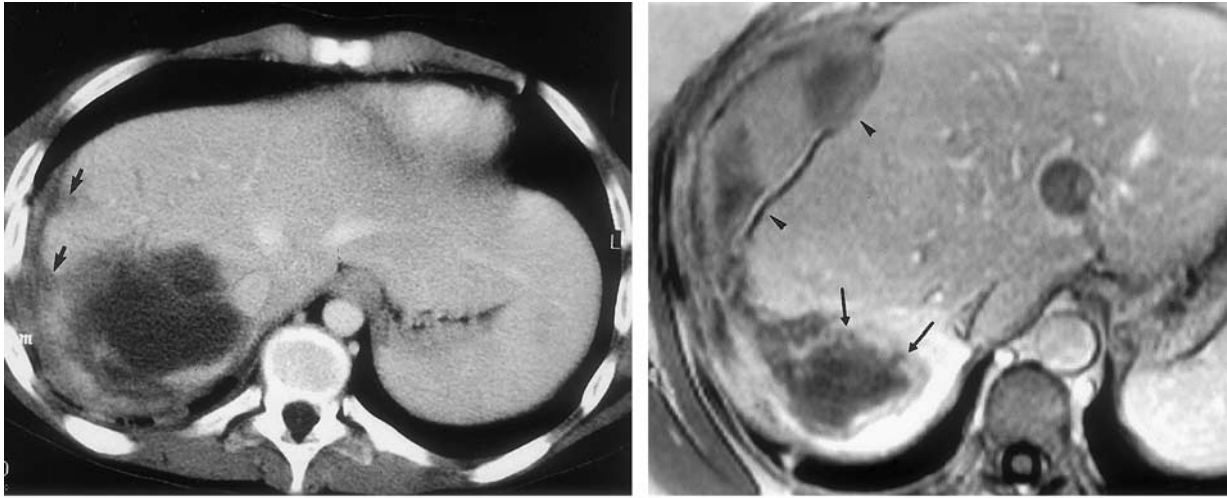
Hepatic hematoma. (a) Portal-venous-phase contrast-enhanced CT scan obtained in a 43-year-old assault victim shows a low-attenuation parenchymal hematoma in the posterior segment of the right hepatic lobe, with coexisting small irregular liver lacerations (arrows). (b) Portal-venous-phase gadolinium-enhanced T1-weighted MR image obtained in a 27-year-old woman shows a “cystic” mass (arrows) in the right hepatic lobe with coexistent acute subcapsular hemorrhage (arrowheads). Consequent laparotomy revealed a bleeding hepatocellular adenoma.
